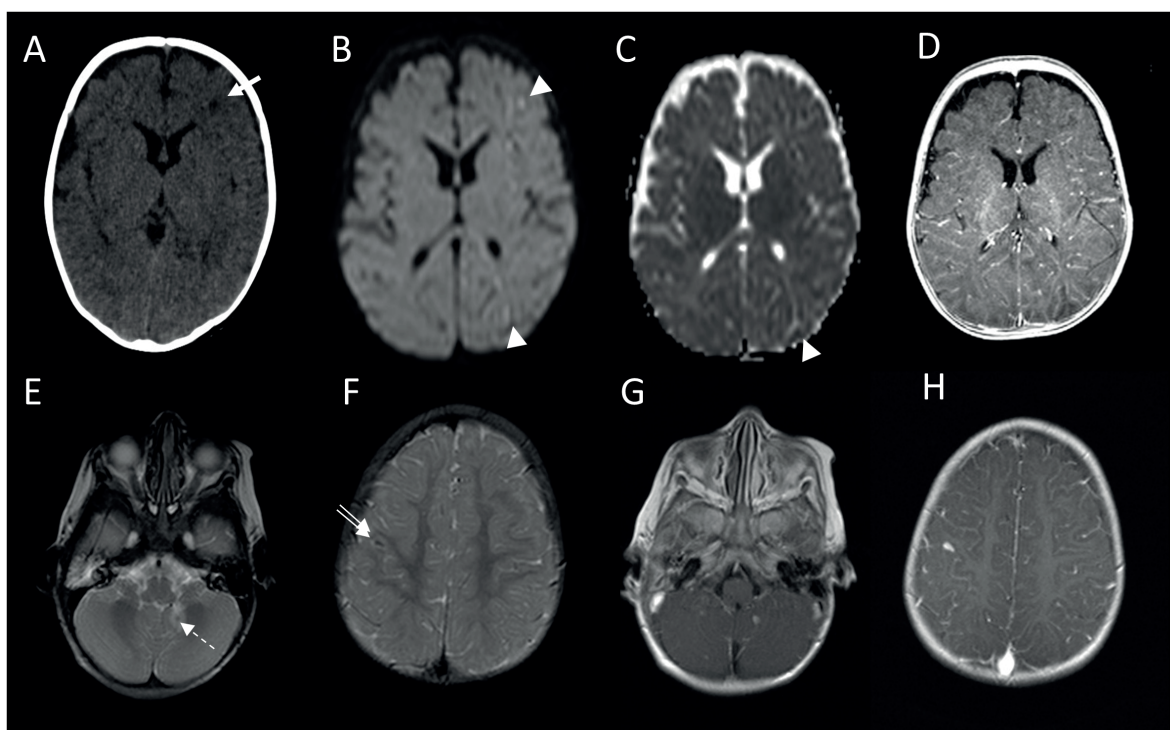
Images of a child at the age of 5 months (upper row; A to D) and 15 month-old (lower row; E to H) child presenting to Pediatric Emergency Department with focal seizures. Nonenhanced CT of the patient shows nonspecific subtle left frontal periventricular hypodensity (A, arrow) while MRI obtained 6 hours later shows left frontal and parietal cortical tiny foci of diffusion restrictions and diffuse pial enhancement on diffusion-weighted imaging (B, C, arrowheads) and post-Gadolinium T1W image (D). Lower row shows nodular T2 hypointense lesions in the left medial cerebellar hemisphere (E, dashed arrow) and right frontal cortical (F, double arrow) which enhance on post-Gadolinium T1W series (G, H). Please note increased number of lesions are seen on post-contrast imaging. These patients received diagnosis of meningoencephalitis (upper row) and CNS tuberculosis (lower row) lesions.
